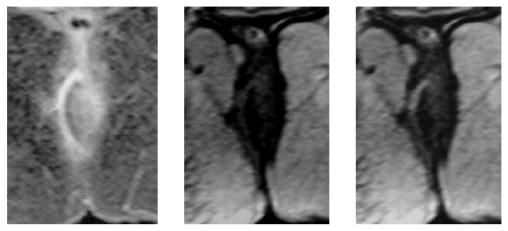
A case of suprasphincteric perianal fistula. Coronal short inversion time inversion recovery (STIR) sequence MR imaging showed high signal intensity fistula tract. T1 weighted images showed low intensity of the tract which increases after contrast enhancement suggesting recurrence.
